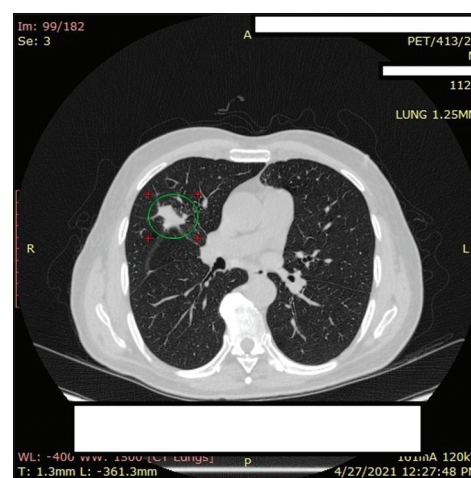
Computed tomography chest showing nodule with irregular margins
